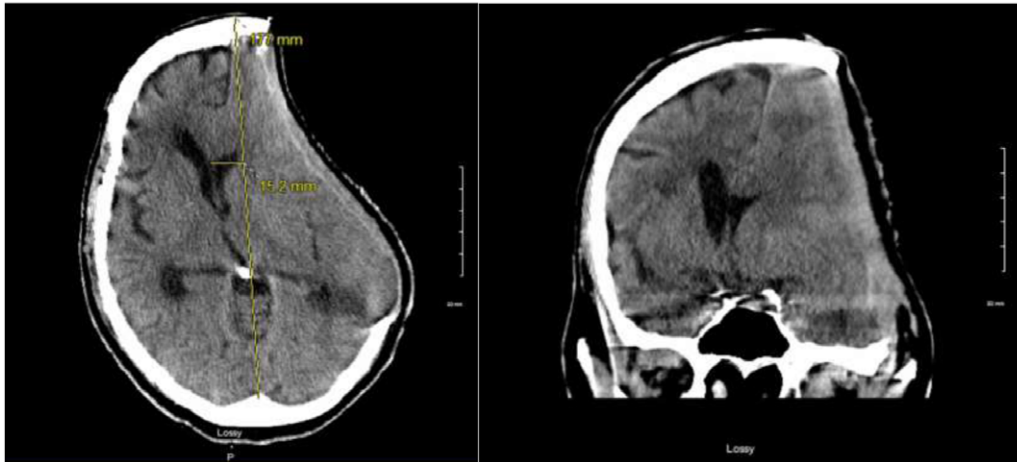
CT non-contrast axial (left) and coronal (right) views of sunken craniectomy site with associated midline shift.
